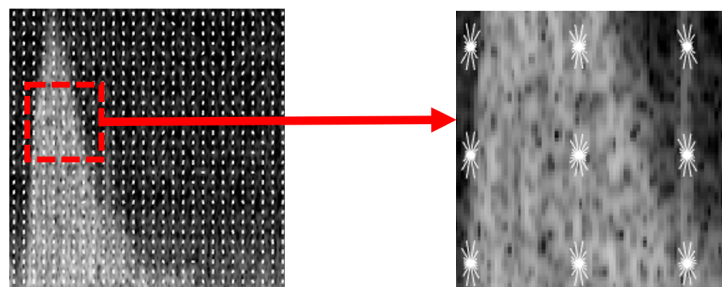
Example HOG features extracted from Doppler image
